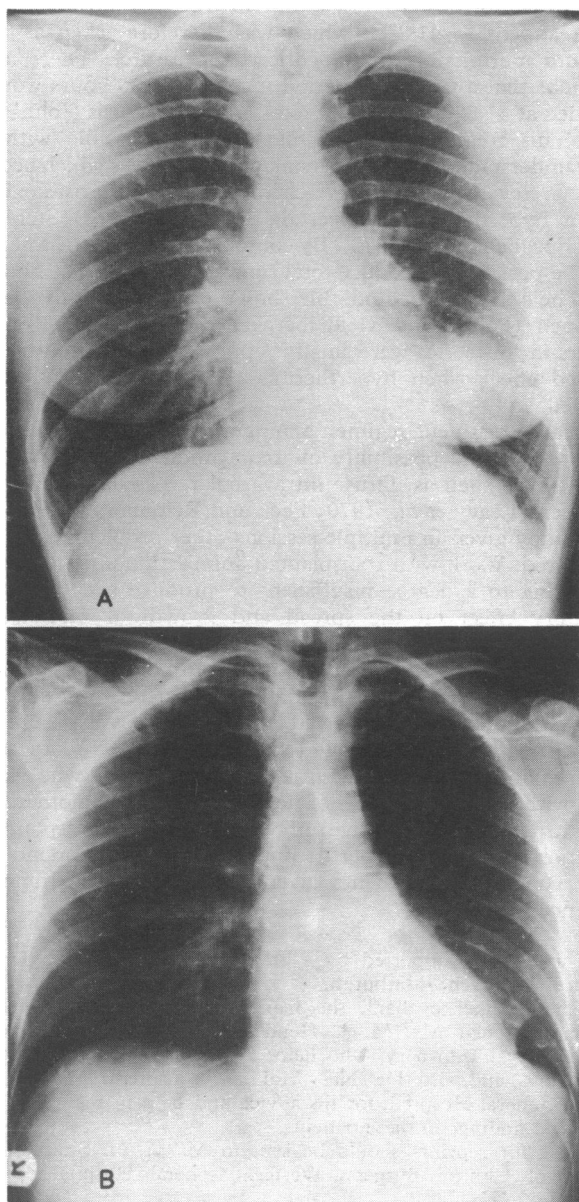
Chest x-ray pictures from patient with bronchogenic carcinoma. A, appearances before treatment with hyperthermia. B, appearances six weeks later after six treatment sessions.
